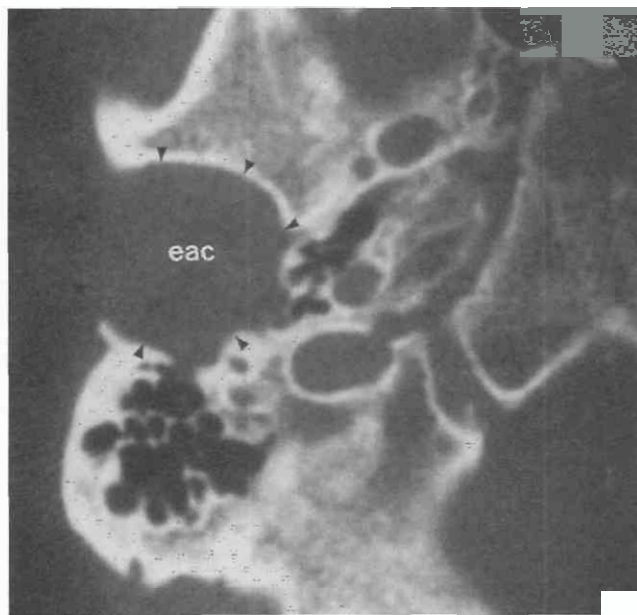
Epidermoid of the external auditory canal in a young man presenting with a chronic history of bilateral external canal obstruction. He had no history of chronic infection or tympanic membrane rupture (as would be seen with cholesteatoma). The axial CT scan through the right external auditory canal (eac) shows a smoothly marginated mass (arrowheads) expanding the canal. The mastoids and protympanum are intact without inflammatory changes.
